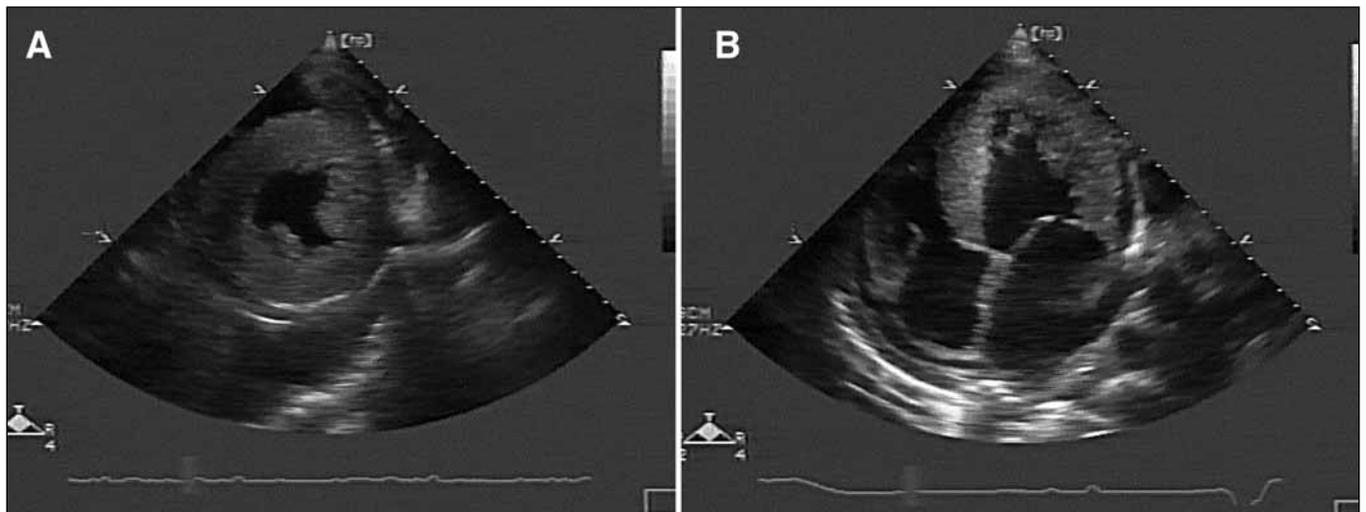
Echocardiography showing moderate to severe concentric left ventricular hypertrophy in the short-axis view (A) and apical four-chamber view (B)
